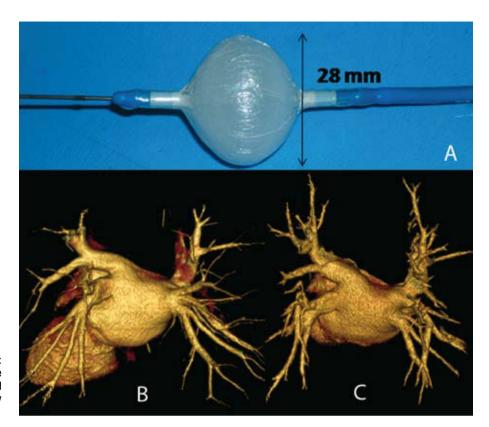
A: inflated balloon catheter. B: computed tomography (64 slices) of the pulmonary veins, case no. 5. C: computed tomography (64 slices) of the pulmonary veins, 3 months postablation, case no. 5.
